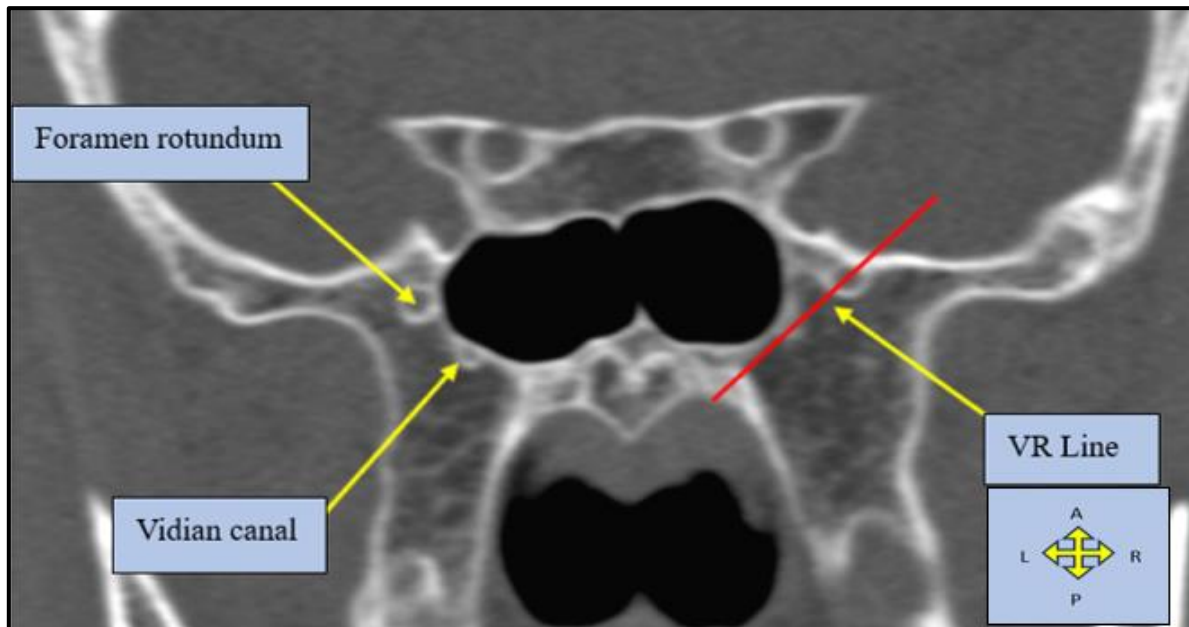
Coronal CT scan showing anatomical landmarks for the VR line (red line), used for classification of lateral extensions of the SS.
